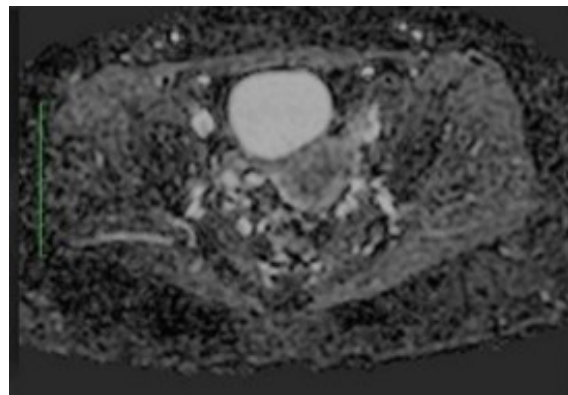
PELVIC MRI SHOWING A COMPLEX CYSTIC LESION IN THE LEFT OVARY, SUGGESTIVE OF AN OVARIAN TERATOMA.
